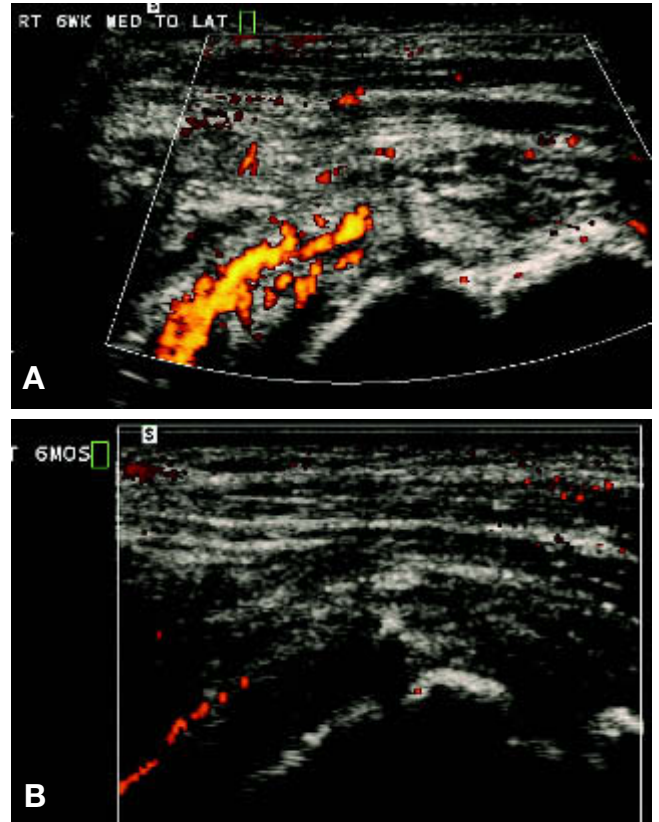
A, postoperative ultrasound performed at 1 month (time #1), demonstrating relatively high-flow state in an intact rotator cuff repair; B, postoperative ultrasound performed at 6 months (time #3) on the same patient, demonstrating relatively low-flow state in an intact rotator cuff repair. Scan was performed in the same arm position.
